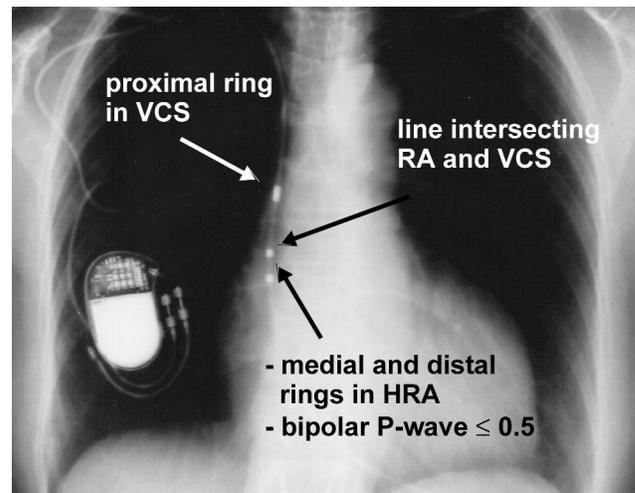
X-ray showing proper positioning of the rings. The proximal ring is located in the VCS and serves as counter electrode, while the other two rings remain in the high right atrium for bipolar sensing. The line intersecting atrium and VCS is located between proximal and medial ring.
